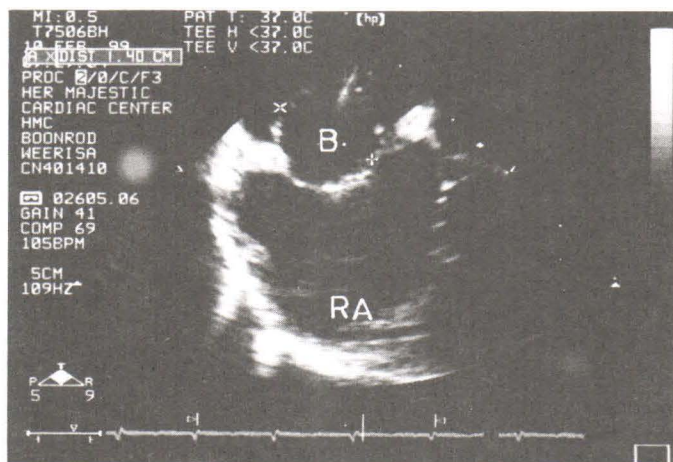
Transesophageal echocardiogram (TEE) short-axis view showing balloon sizing method: RA right atrium, B balloon.
